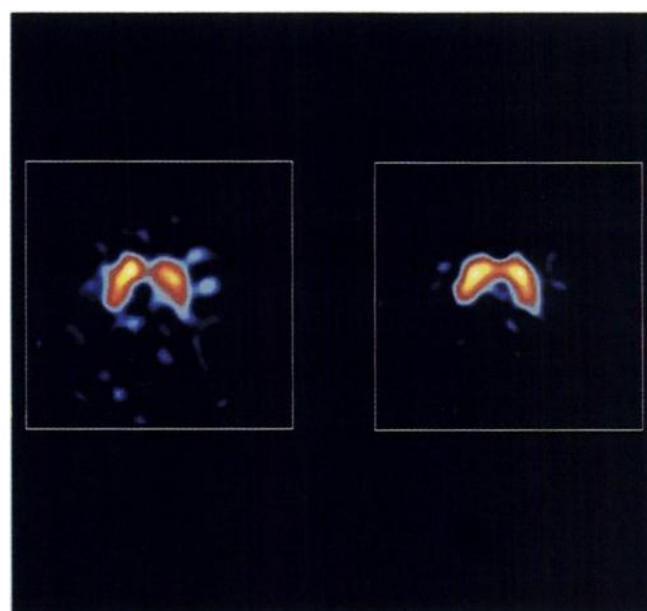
Transaxial brain SPECT images acquired at 5 and 24 hr post-[^{123}I]β-CIT injection in a healthy human subject. Images are the sum of four adjacent slices demonstrating highest striatal activity (see text for acquisition and processing data). The 5-hr image shows a midline focus of activity immediately posterior to striatum, which may represent midbrain uptake.
